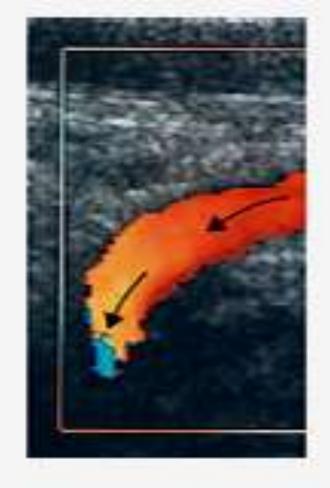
An internal carotid artery as it dips deep in the neck. As the path of the artery changes relative to the Doppler beam (shown by the arrow), the relative velocity (Doppler frequency) detected will alter, leading to a change in the color displayed, despite the fact that the velocity of the blood flow has not changed.
